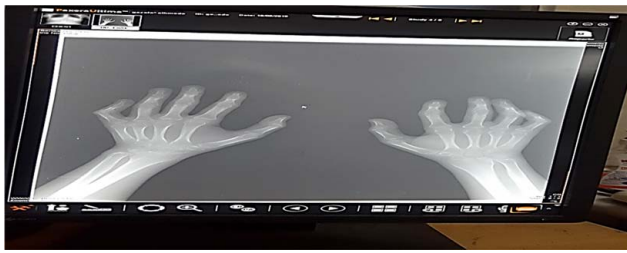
X-ray of hands.
